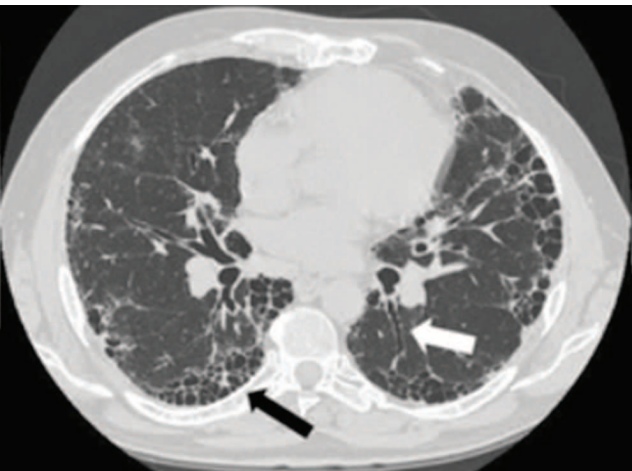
Typical manifestations of IPF on CT sections of the chest (the black arrow shows the «honeycomb lung», the white arrow shows traction bronchiectasis) [11]
